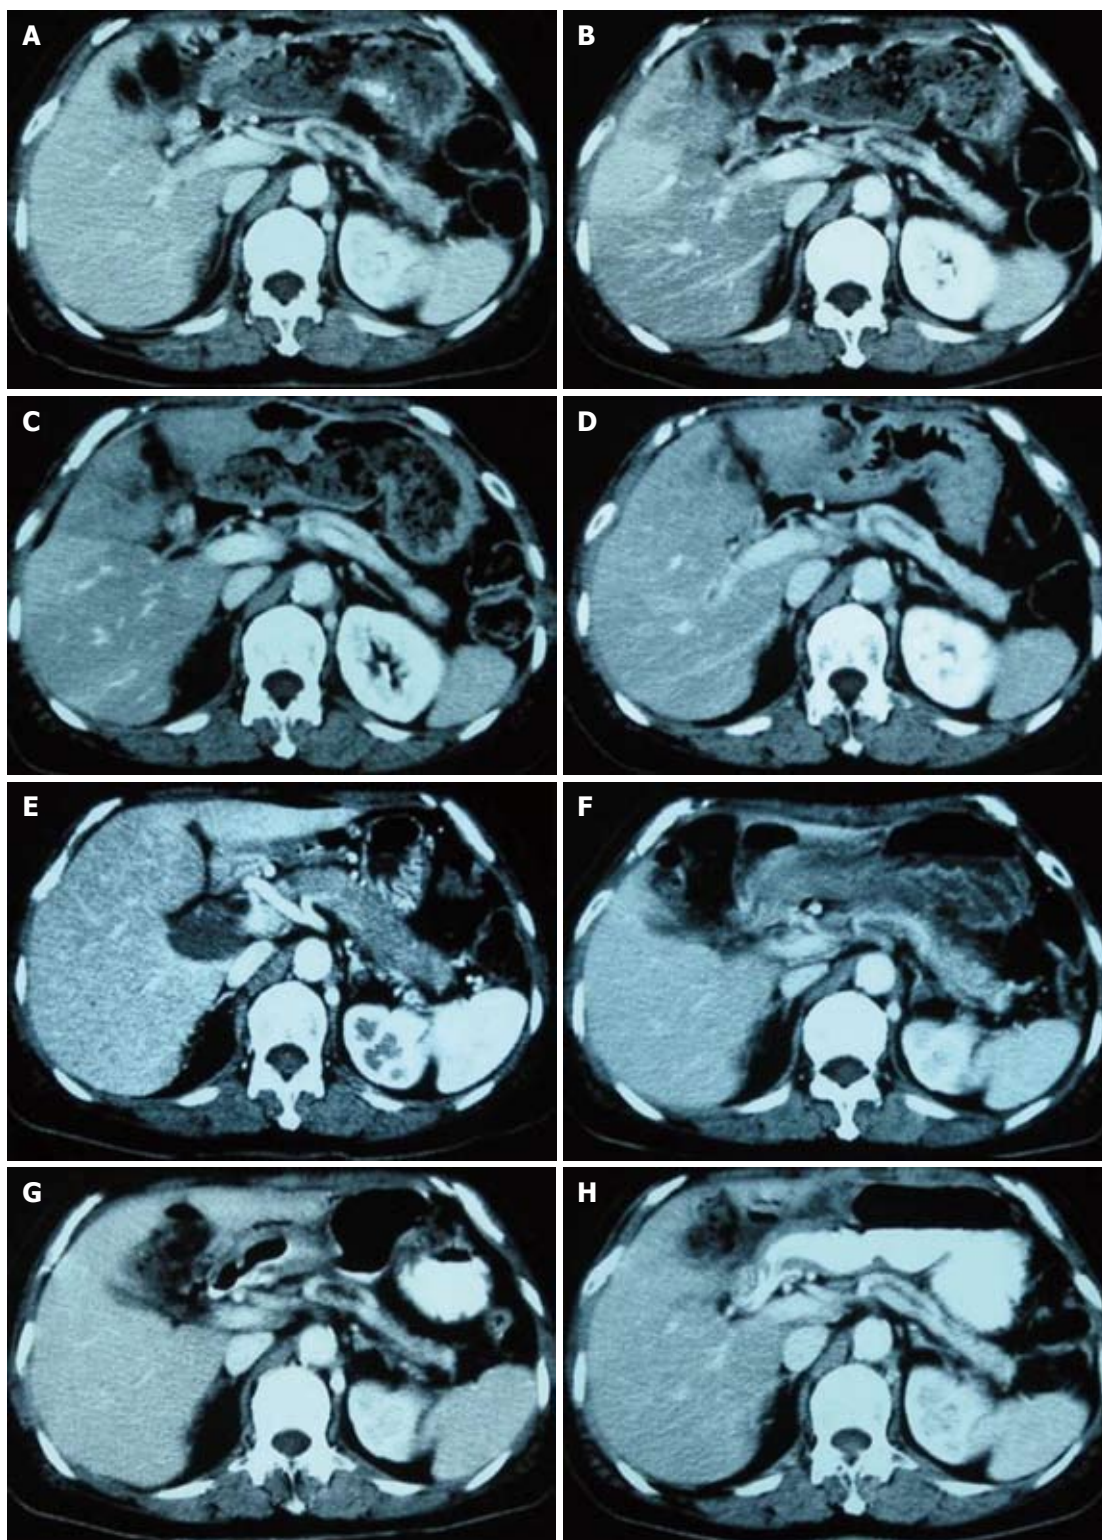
Abdominal CT. A: 12 mo after CTx; B: 16 mo after chemotherapy (CTx); C: 18 mo after CTx; D: 24 mo after CTx; E: preoperative; F: 1 mo after CTx; G: 2 mo after CTx; H: 6 mo after CTx; CT: Computed tomography; CTx: Chemotherapy.
